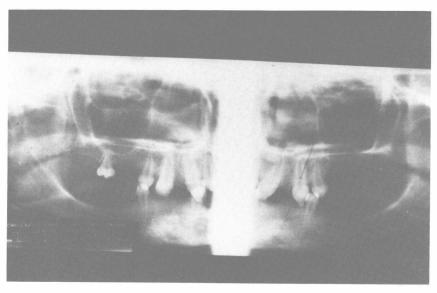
Radiographs of the dentition of a patient with ectodermal dysplasia.
